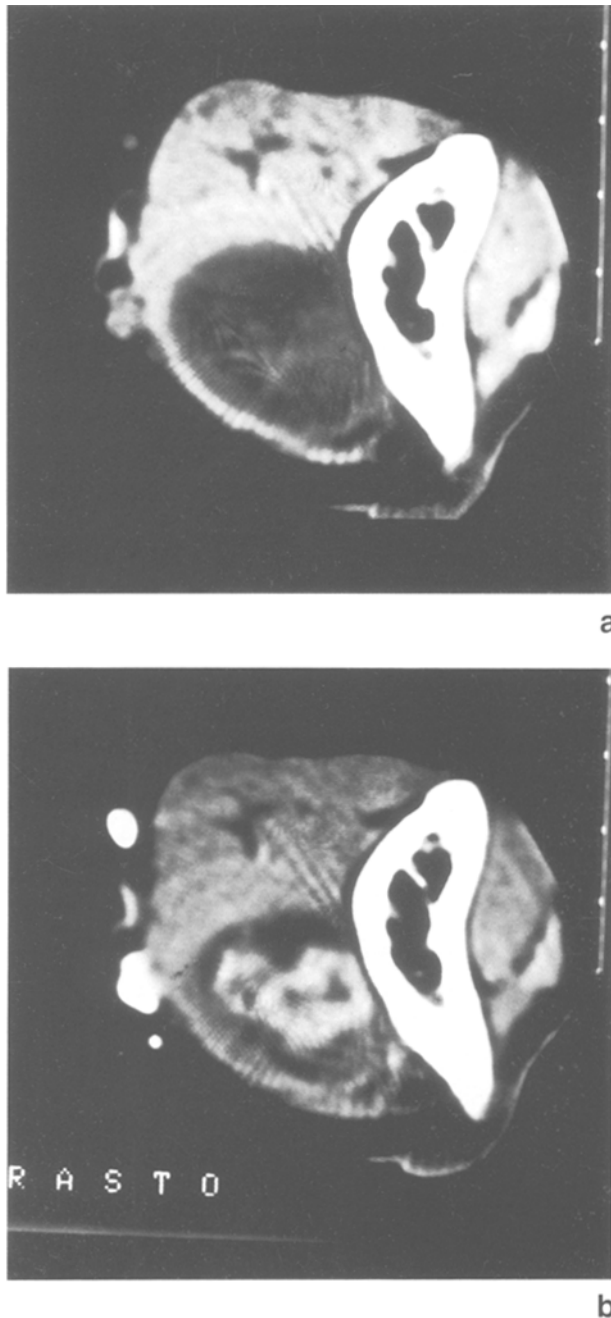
(a,b) CT scan of neurofibroma of the right median nerve: tumour with lower attenuation (a) than surrounding muscles, heterogeneously enhanced (b) by contrast medium
